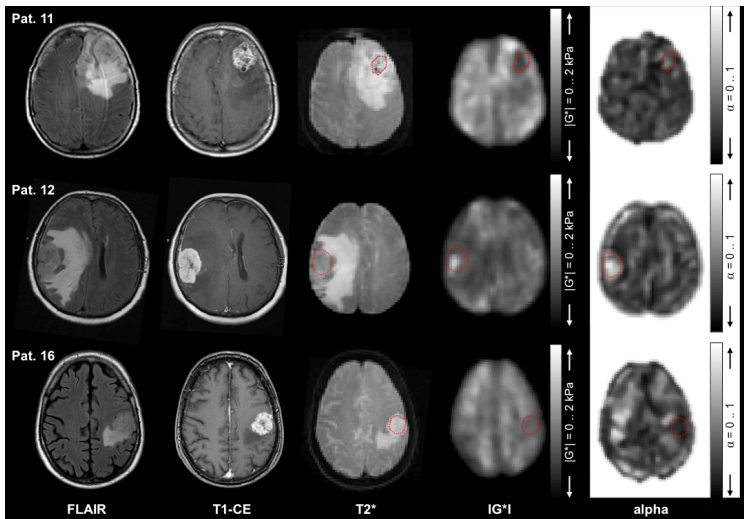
Anatomical scans and parameter maps of three cases with high similarity on conventional MRI: Patient 11 presented with an anaplastic oligoastrocytoma (WHO III); patient 12 with a benign meningioma (WHO I); and patient 16 with a high grade glioblastoma (WHO IV). In contrast to the similarity on the anatomical conventional MRI, the biomechanical properties distinctly differentiate the tumor entities as visible on the parameter maps already by the naked eye. The regions-of-interest (ROI) are demarcated as red dotted lines.
